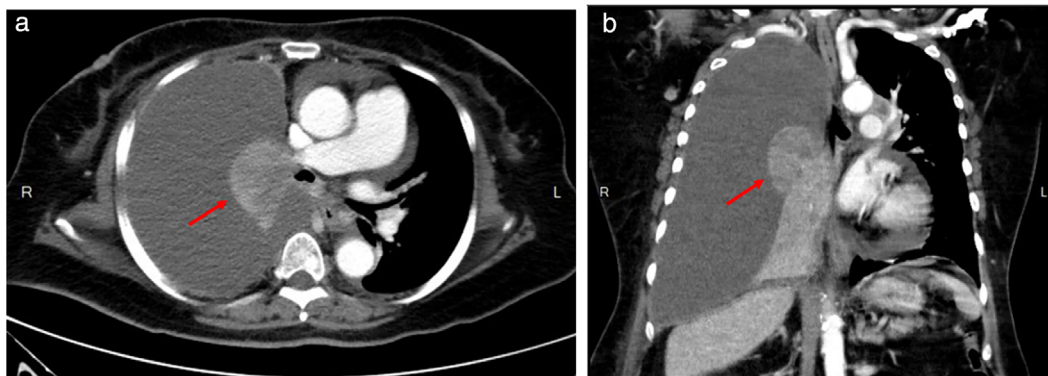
Initial chest CT with contrast enhancement revealed a mass lesion (3.55 cm) over the right upper lung with a massive right-sided pleural effusion, bilateral mediastinal lymph node enlargement, and a nodular lesion over the left upper lung
